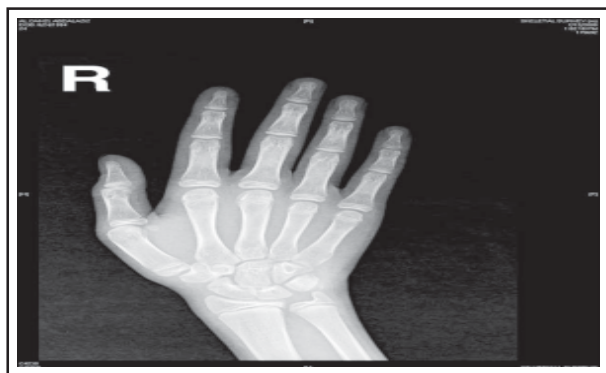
X-Ray right hand.
